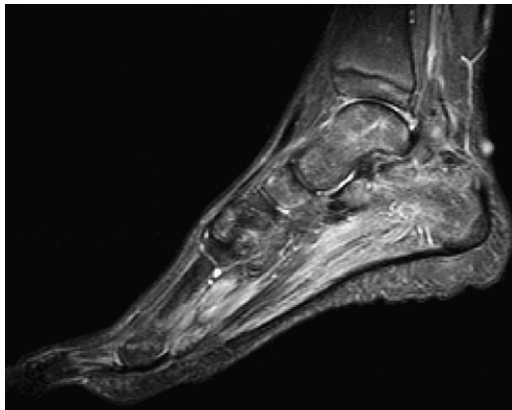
Sagittal T2-weighted image of the foot in a 12-year-old patient who underwent prior resection of a synovial sarcoma with secondary posterior tibial nerve dysfunction. There is increased T2 signal in the intrinsic plantar muscles of the foot from denervation (muscle edema).
